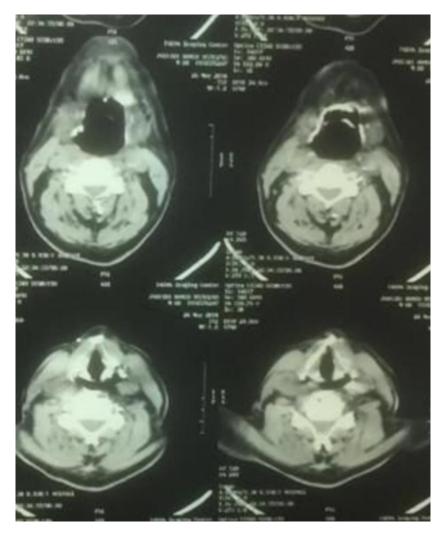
Air-filled masses around the false cords were observed on Computed Tomography (CT) scan
